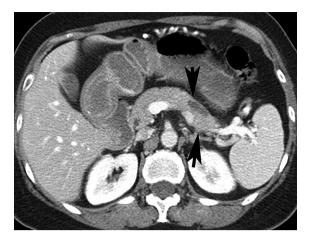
Axial computed tomography scan showing a distal pancreatic lesion (arrows) with cystic changes and ductal dilatation.
